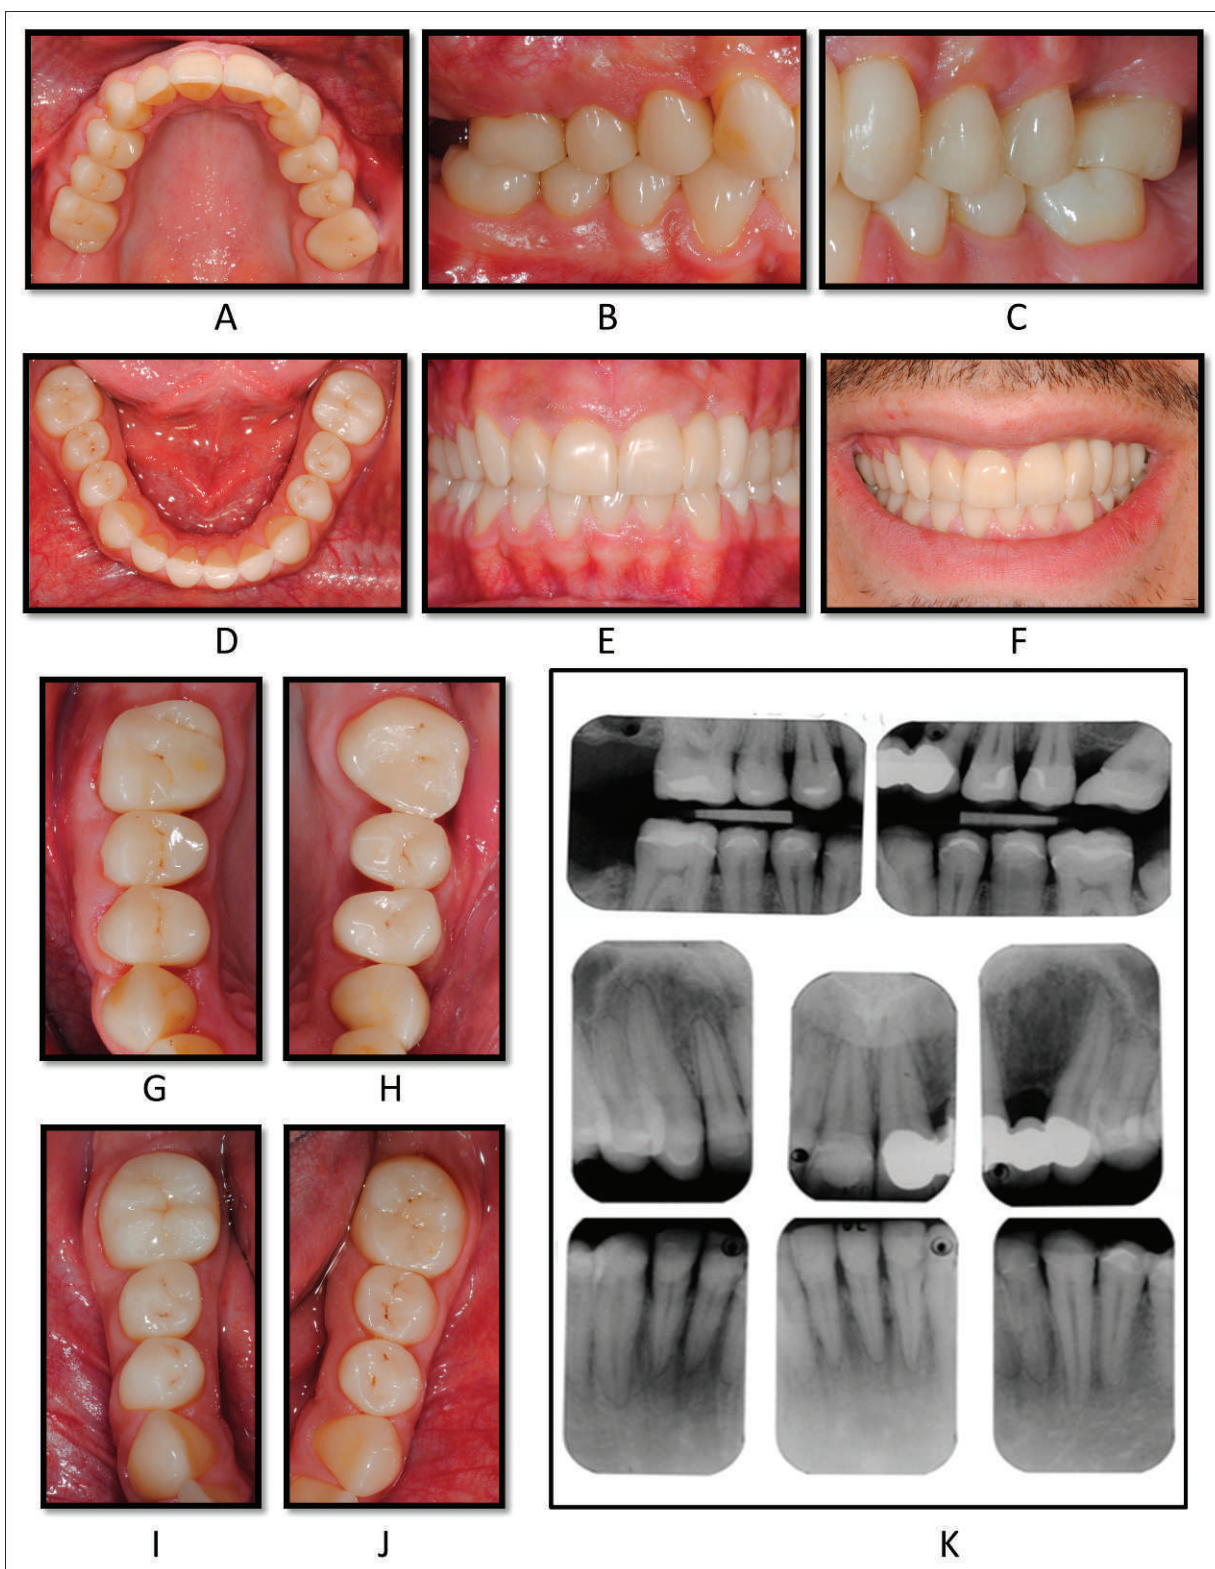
(a-k): Clinical views at the end of the treatment, together with the final treatment status at the 3-month recall. Except for the lithium disilicate bridge from 21–23, all other teeth are single-unit lithium disilicate bonded crowns. The last image represents the final radiographic status.
